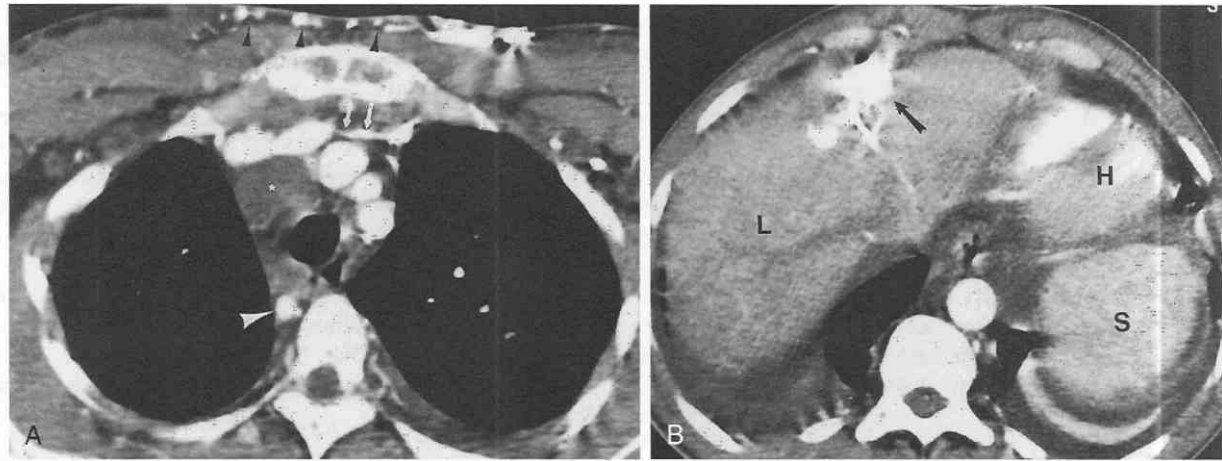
Collateral venous channels in a patient with thrombosis of the left subclavian vein caused by an indwelling catheter. *A*, Contrast-enhanced CT shows narrowing of the left subclavian vein (arrows), numerous enlarged veins in soft tissues of the chest (small arrowheads) and paravertebral region. The large arrowhead indicates an enlarged right superior intercostal vein, and the asterisk indicates paratracheal adenopathy. *B*, Contrast-enhanced CT shows collateral venous drainage in the recanalized umbilical vein (arrow). Bilateral pleural effusions can be seen. L, liver; H, heart; S, spleen.
